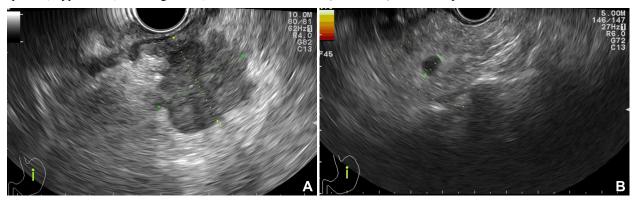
Endoscopic ultrasound. Pararectal mass of 2.4/3/3 cm, hypoechoic, inhomogeneous, in contact but with no invasion of rectal layers (A) and pararectal lymph nodes (B).
